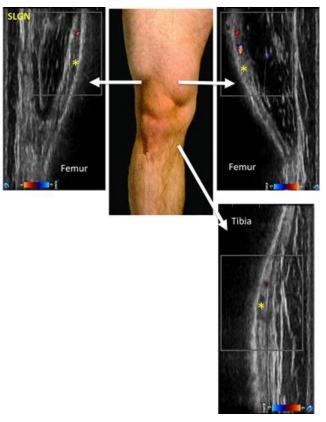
Ultrasound probe position and corresponding images for genicular radiofrequency treatment. Color Doppler shows the corresponding genicular arteries. Treatment sites are marked with yellow asterisks.
